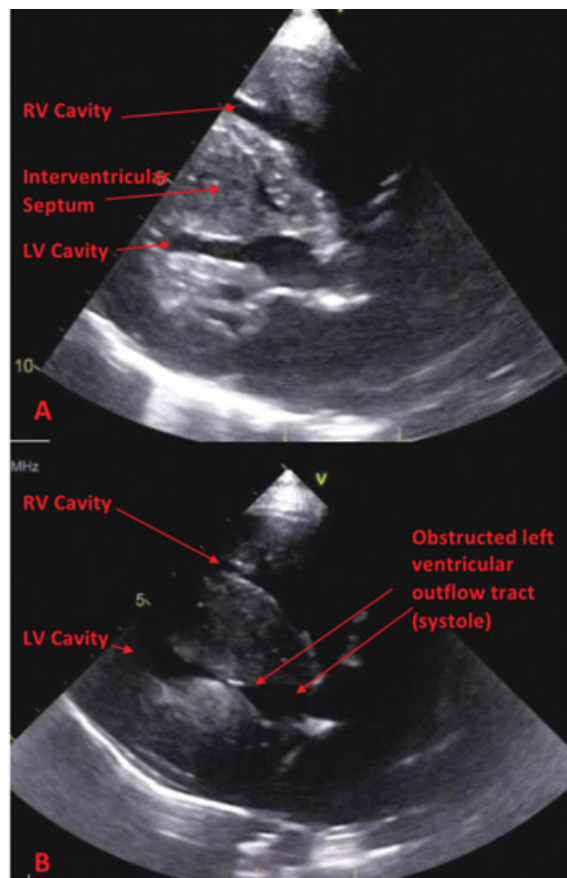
Preoperative transthoracic echocardiography in parasternal long axis view demonstrating (A) severe right and left ventricular cavity obliteration from thickened ventricular free wall and interventricular septum and (B) dynamic obstruction of the left ventricular outflow tract. Courtesy of Adam C. Adler, MD.
